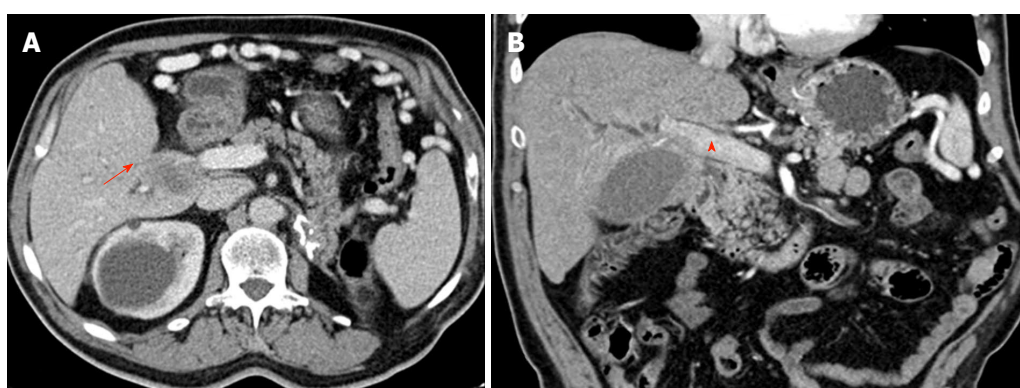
Preoperative CT images from case 3 demonstrating a dilated intrahepatic bile duct (arrow, A) that ends abruptly at the biliary confluence. An ill-defined hilar mass is seen infiltrating the right hepatic artery (arrow, B) and bilateral hepatic ducts and contacting focally with the portal vein (arrowhead, B).
